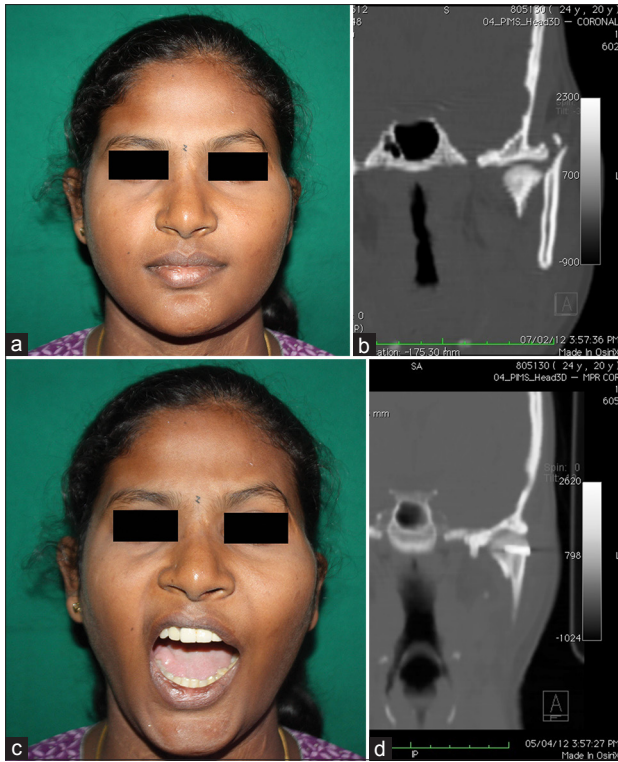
(a) High left condylar fracture with displacement (b) pre-operative computed tomography facial bone showing left high condylar fracture with displacement (c) post-operative intermaxillary fixation (arch bars) and open reduction and internal fixation of fracture with a screw through pre-auricular approach showing adequate mouth opening (d) post-operative computed tomography facial bone showing good reduction of fracture with screw *in situ* (Patient Consent has been obtained for Photo usage with identity concealed)
